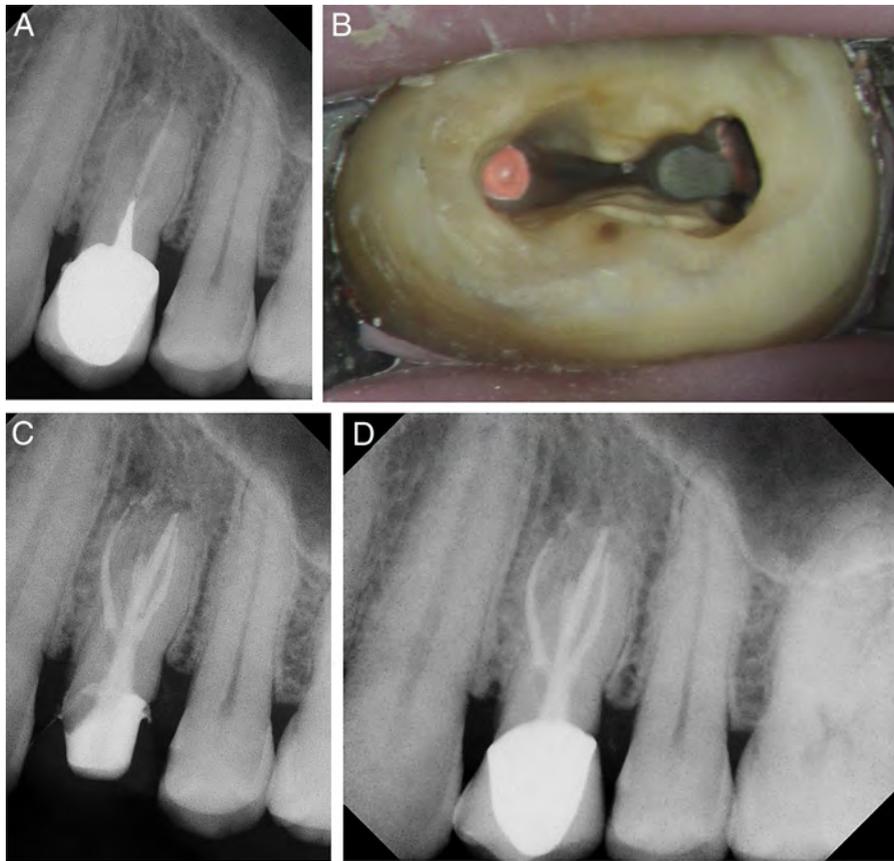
Case 3. (A) A preoperative radiograph of tooth #12 showed periapical radiolucency and missed canal systems. (B) After disassembly, a furcal perforation of the buccal roots was visualized and sealed with MTA. The canal system was retreated and obturated with warm gutta-percha. (C) A postoperative radiograph. (D) At the 1-year recall, the tooth was asymptomatic, functional, and restored with a PFM crown. The radiograph showed no evidence of endodontic disease.
